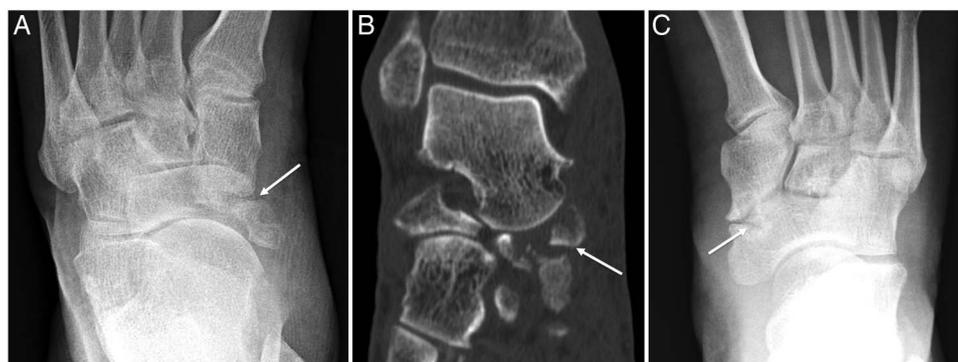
Images showing navicular injuries. (A) Acute navicular fracture on anteroposterior radiograph (arrow); (B) acute comminuted navicular fracture on plantar flexion positioning coronal CT (arrow); (C) linear lucency anteromedial navicular rimmed by sclerosis, compatible with stress fracture (arrow) are shown. This stress fracture is in an atypical location, but with a classic radiographic appearance.
